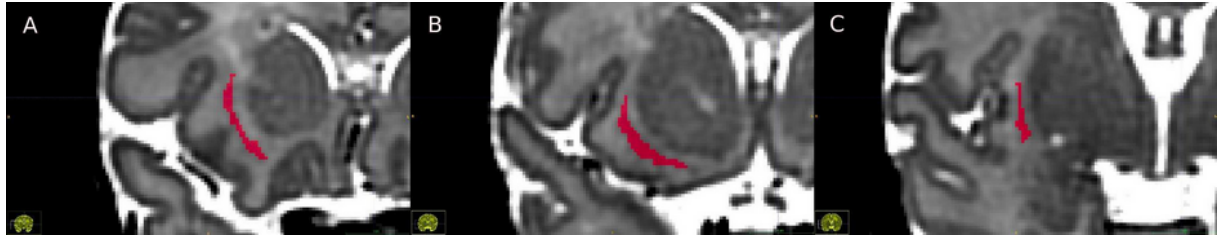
Coronal MRI slices with manual claustrum segmentation.
